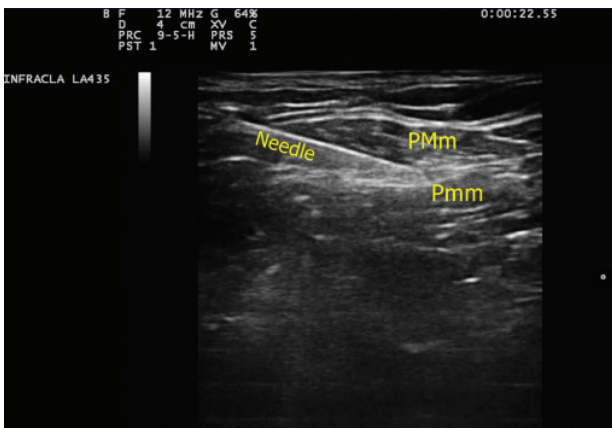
Ultrasound image of needle direction between muscle.
